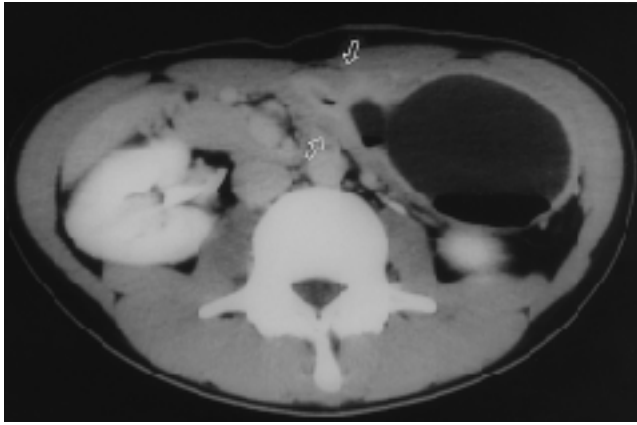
Postcontrast CT scan shows marked submucosal thickening at antrum causing obstruction (arrows).
